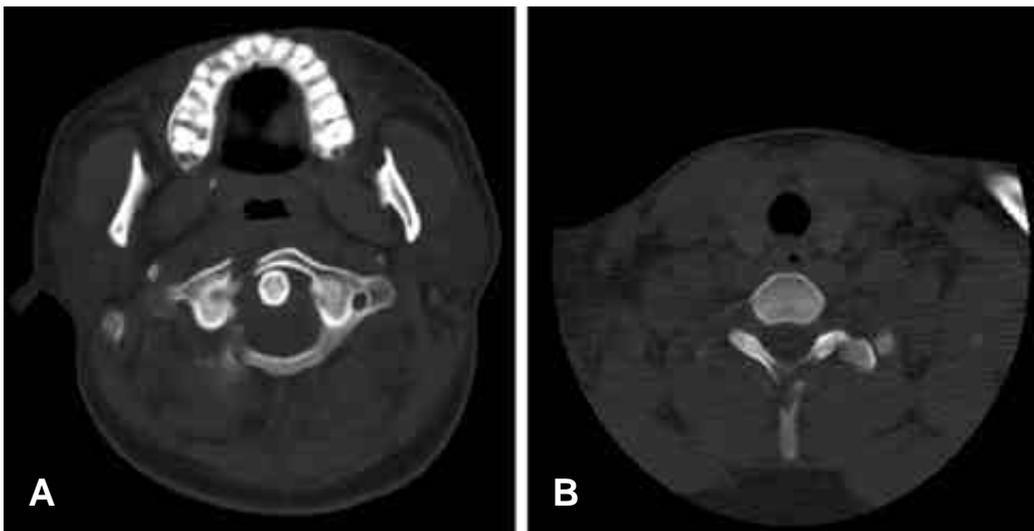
Axial computed tomography scans. It shows Jefferson fracture of atlas, fracture on Rt. anterior & posterior arch of C1 (A) and fracture on spinous process of C7 (B).
